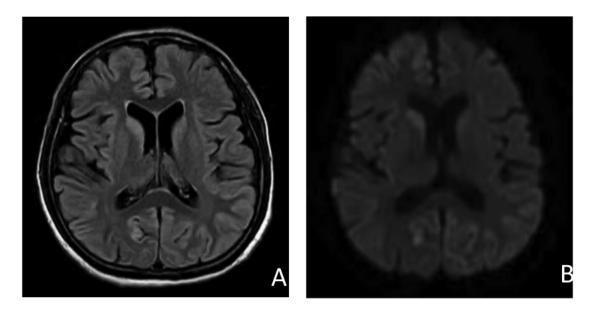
FLAIR (A) and Diffusion-weighted (B) magnetic resonance imaging showing high signal intensity on bilateral precuneus cortices and bilateral medial cortices of parietal lobes. (front-cover page)
